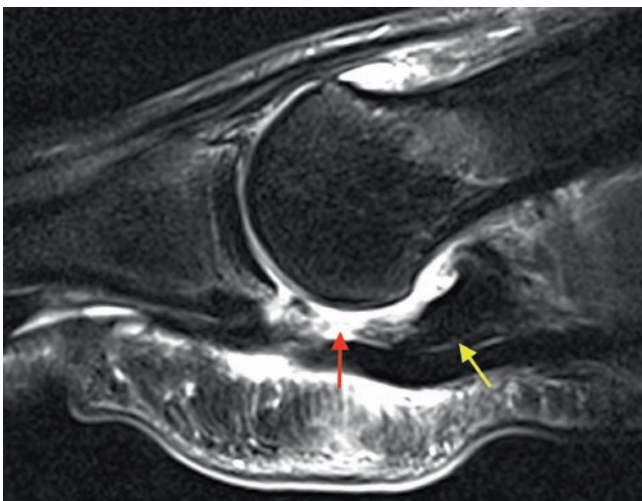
Turf Toe. Sagittal T2(fs) MRI of the 1st MTP joint shows disruption of the plantar mechanism (red arrow) with retraction of the plantar plate (yellow arrow)
